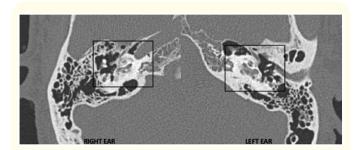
High resolution computed tomography (HRCT) temporal bone reveals bilateral Halo sign. (Rotteveel Grade 2C).
